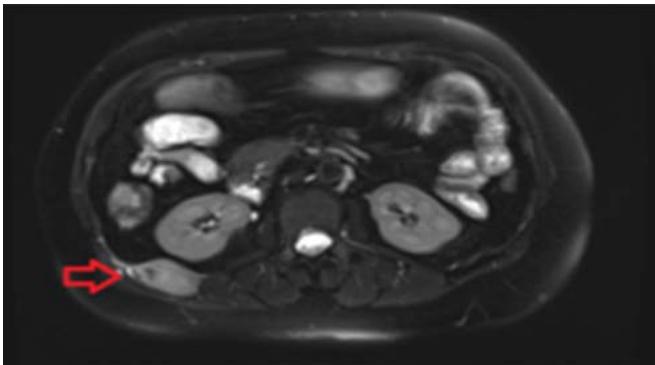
MRI showed a markedly increased uptake mass on the last right thoracic rib measuring 30x40mm. The mass showed heterogeneous medium and high signal intensity on T2-weighted images.
